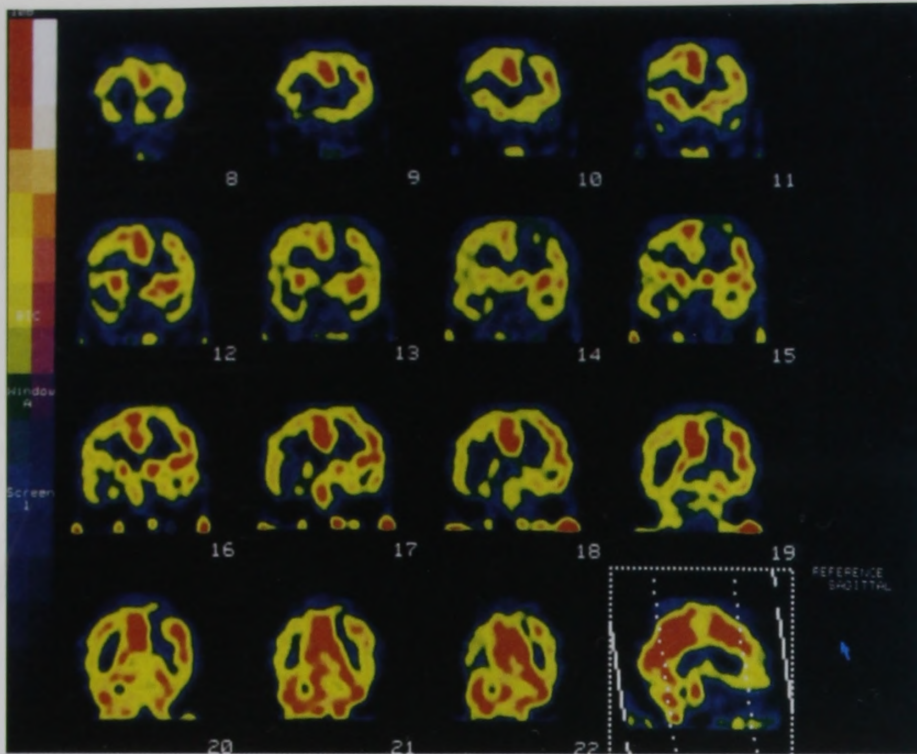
Coronal views of single photon emission computed tomographic scans using ^{99m}Tc -ethyl cysteinate dimer obtained 92 months after radiosurgery, showing a hypoperfused area in the left parietal region, which was surrounded by a slightly hyperperfused area.
